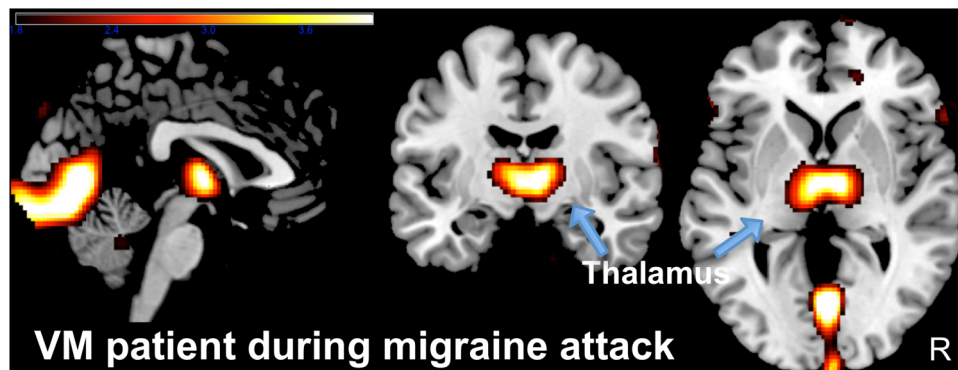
To analyze the cerebral blood glucose utilization during an actual VM attack a FDG-PET was performed in a 35-year-old patient suffering from VM according to the consensus criteria [8, 9] (ECAT Exact PET Scanner, Siemens/CTI, Knoxville, USA, with a ^{18}F -fluorodeoxyglucose [FDG]-tracer in a three-dimensional acquisition mode). During the attack the patient presented with a central positional nystagmus beating oblique (up- and leftward) and increasing in different head/body positions (supine, left ear down, right ear down). Both, nystagmus and vertiginous sensation, persisted for 72 h and resolved spontaneously without any ongoing vestibular or ocular motor dysfunction. In addition, a structural T_1 -weighted MRI (MPRAGE sequence, 180 slices, slice thickness = 1 mm, image matrix = 256^2 , TR = 9.7 ms, TE = 4 ms) was acquired in a clinical
